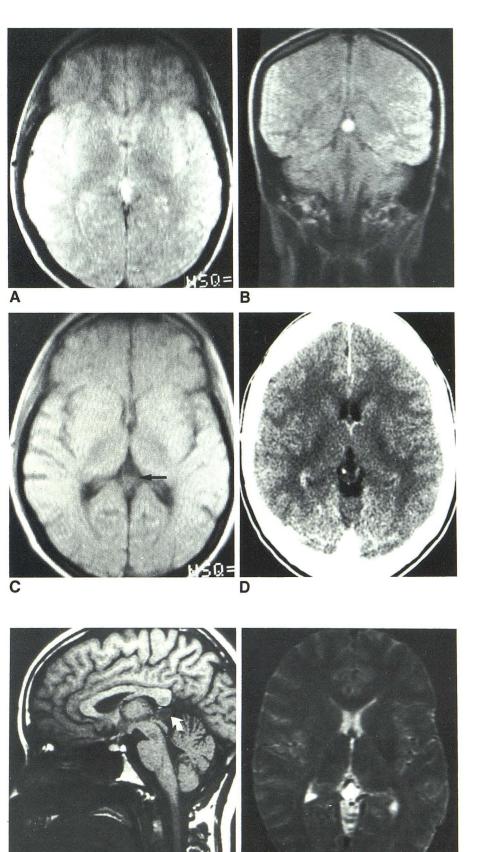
A, Sagittal T1-weighted image at 1.5 T reveals large pineal cyst. Rim has relatively higher signal than cyst contents (*arrow*). B, T2-weighted (TR 2000, TE 80 msec) image. Cyst can be identified by its high intensity.
